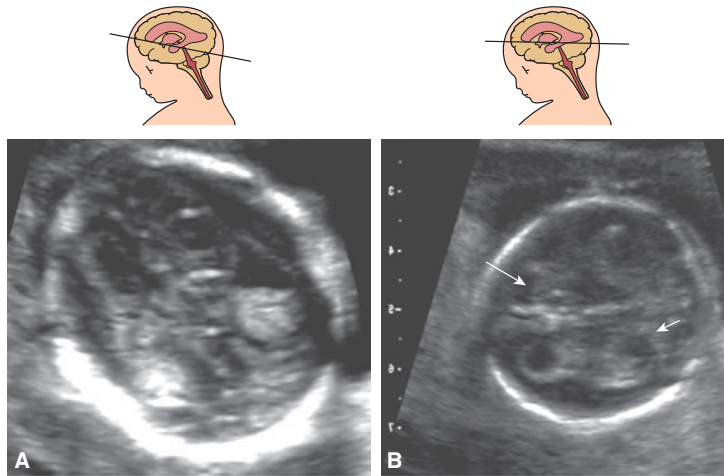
Intracranial hemorrhage at 16 postmenstrual weeks. (A), (B) The initial sonographic appearance of the “fresh” blood clots is that of homogeneous hyperechoic areas (*large arrow*), which are distinct from the choroid plexus (*small arrow*). The lateral ventricles show a castlike pattern that is brightly echogenic, most likely as the result of blood.
